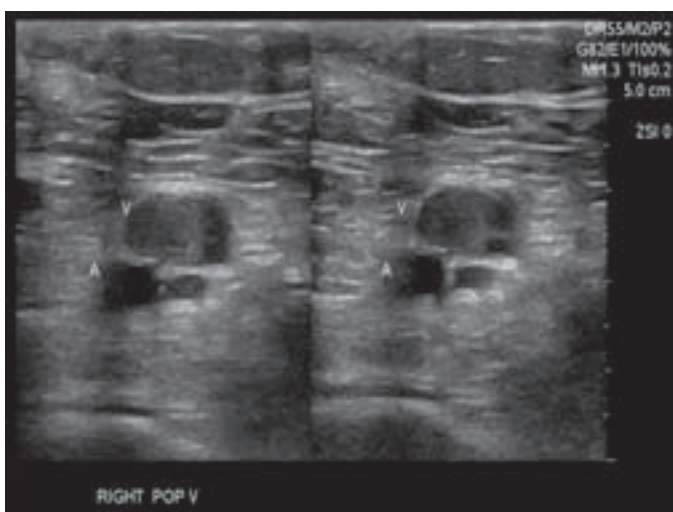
Compression ultrasound demonstrates a patent popliteal artery (A) in both images. A clot can be seen in the popliteal vein (V), which does not collapse during compression (right-sided image).
